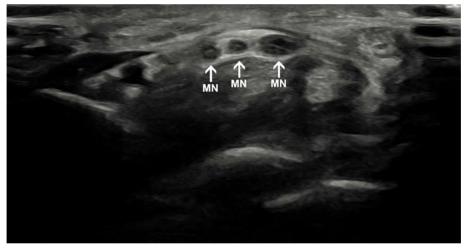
Ultrasound image showing a trifid median nerve (white arrow).
